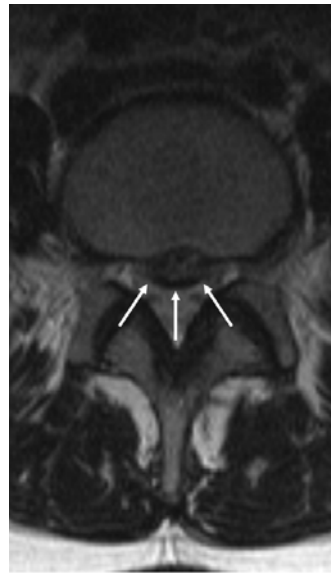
T2-weighted axial image after one year follow-up
